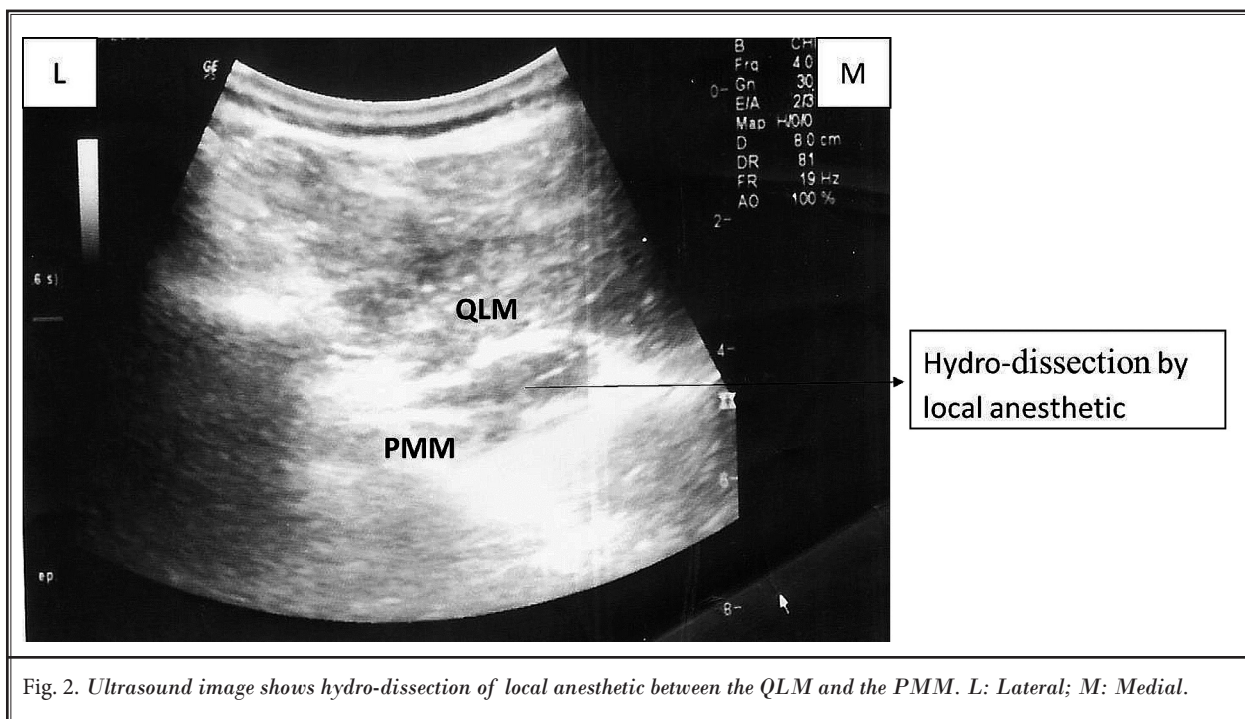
Ultrasound image shows hydro-dissection of local anesthetic between the QLM and the PMM. L: Lateral; M: Medial.
